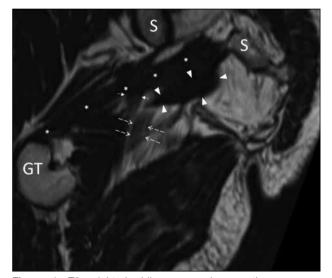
T2-weighted oblique coronal magnetic resonance imaging of pelvis (repetition time: 1500 ms, echo time: 126 ms): The main bulk of the piriformis muscle (asterisks) originates from the anterior sacrum (S) and attaches to the greater trochanter of femur (GT). Aberrant muscle fibres of the piriformis muscle (arrowheads) are noted anterior to the piriformis muscle. The common peroneal division of the sciatic nerve (short arrows) passes between the main bulk and aberrant muscle fibres of the piriformis muscle. The tibial division of the sciatic nerve (dotted arrows) courses deep to and below the main bulk and aberrant muscle fibres of the piriformis muscle.
